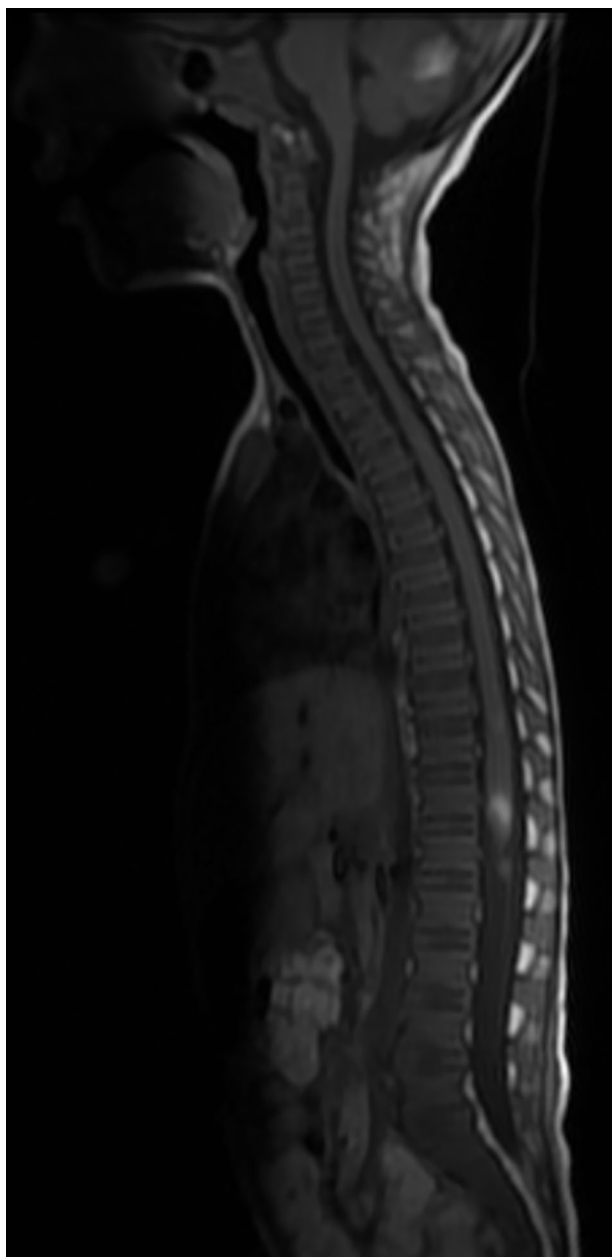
Sagittal T2WI MRI of the spine showing hyperintense area in the intramedullary location of spinal cord at D12–L1 vertebral levels. An intracranial hyperintense area in the cerebellar region is also identified, suggestive of bleed
